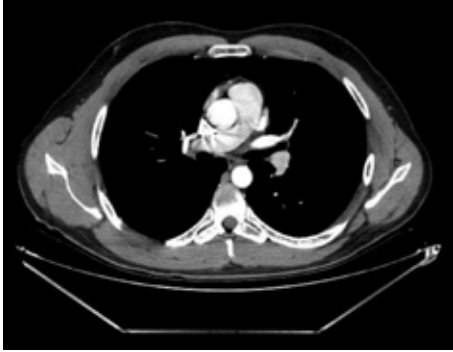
Thorax computed tomography angiography demonstrating thrombus in pulmonary artery.
